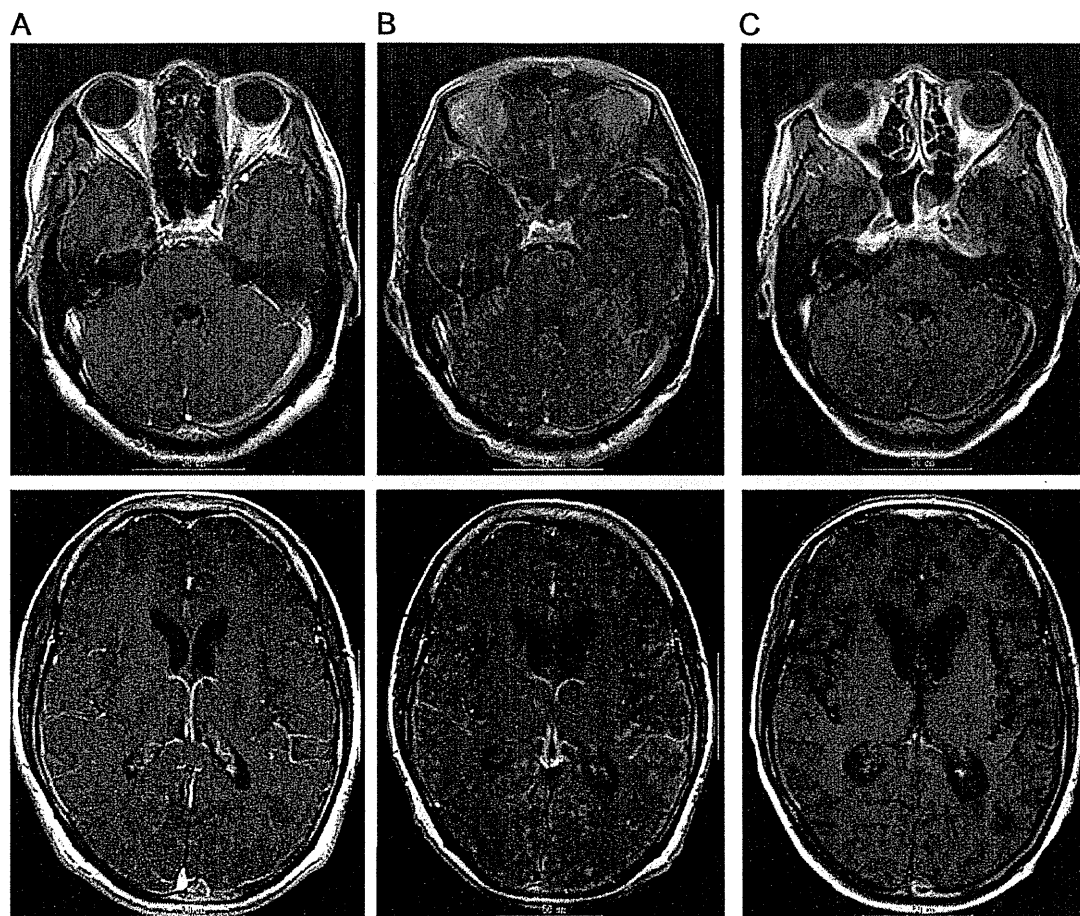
Case 1: Brain magnetic resonance imaging (MRI). A: With gadolinium-diethylenetriamine pentaacetic acid-enhanced MRI at 2 levels, the pons (upper) and basal ganglia (lower) showing no significant change after the patient became comatose. B: Multiple enhanced miliary nodules 1 month after radiation therapy. C: Decrease in brain metastatic lesions 2 months after radiation therapy.
